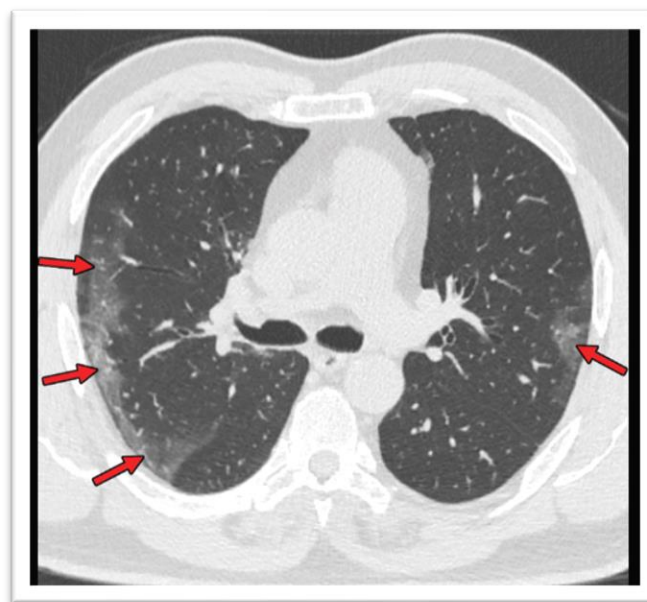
Chest CT Abnormalities with High Incidence (>70%)(27).
